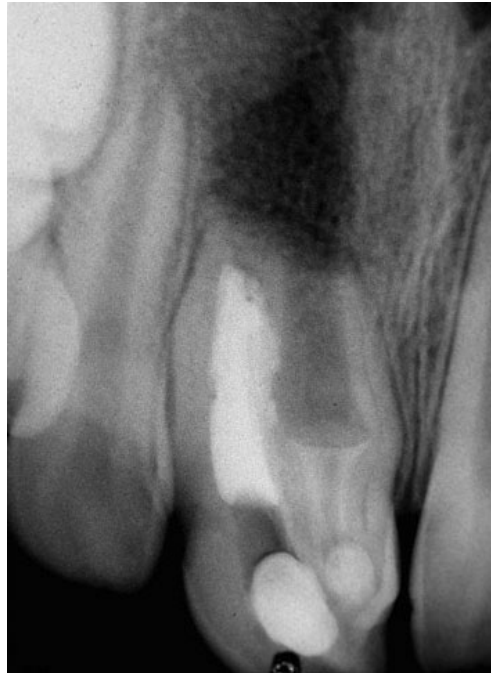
Periapical radiograph shows a type III dens invaginatus. Main canal (MC) and pseudo-canal (PC) are indicated. Apical radiolucence and open apex are also observed.
